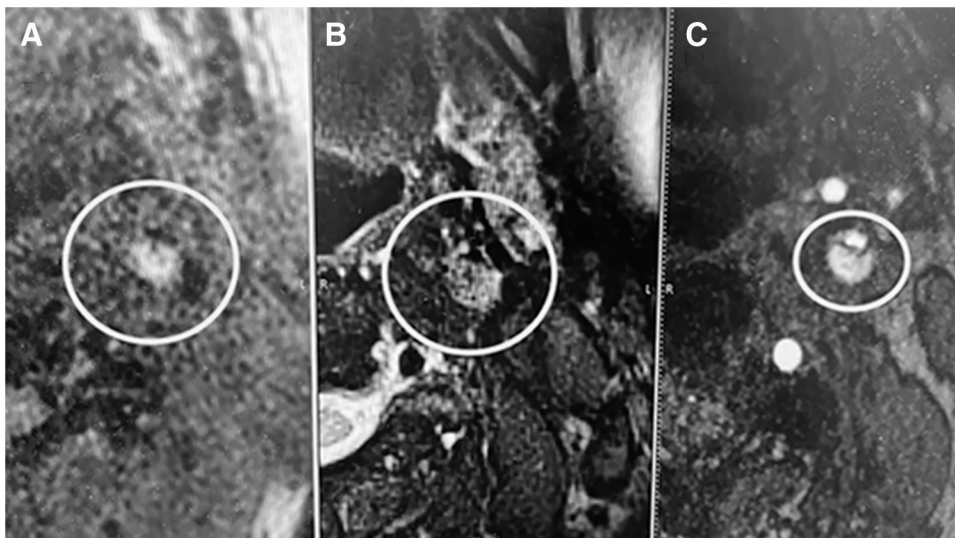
Left cervical MRI plaque axial imaging: T1 (A), T2 (B), and TOF (C). Unstable plaque including intraplaque hemorrhage with T1 high intensity (A), T2 high intensity (B), and TOF high intensity (C), and plaque muscle ratio 3.13 were observed. TOF: time of flight
